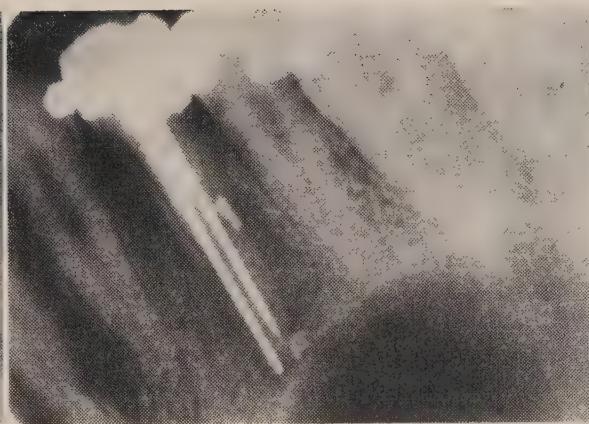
Radiographie d'une incisive centrale avec canal latéral scellé. A noter le confinement du ciment.
